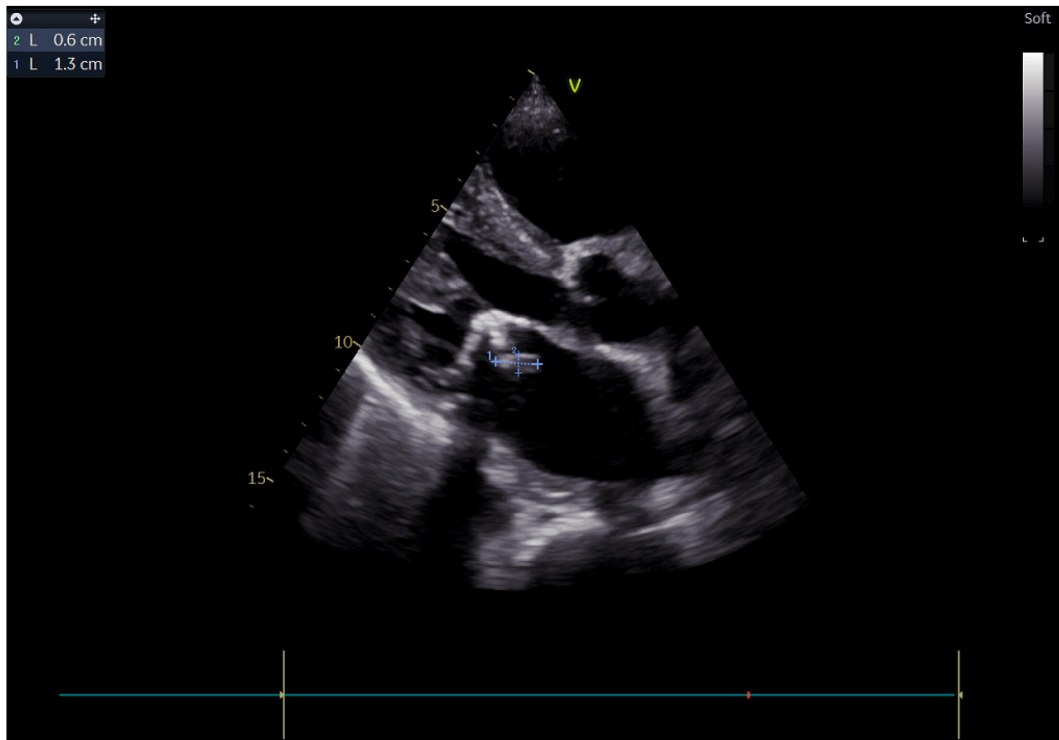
Parasternal long axis view showing the mitral vegetation measuring 6 × 13mm.
